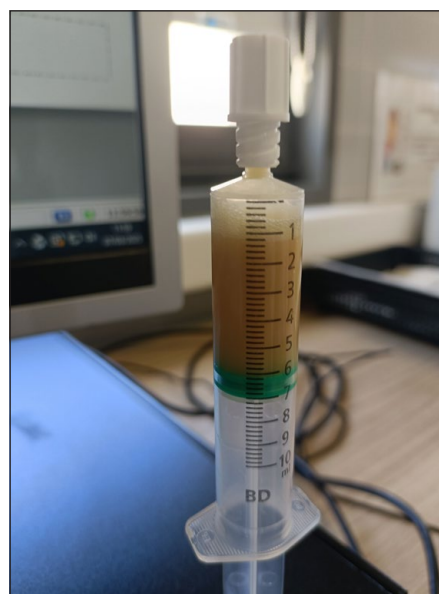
Purulent material (6 mL) obtained by ultrasound-guided percutaneous drainage from cervical lymphadenopathy during TB-IRIS episode.
